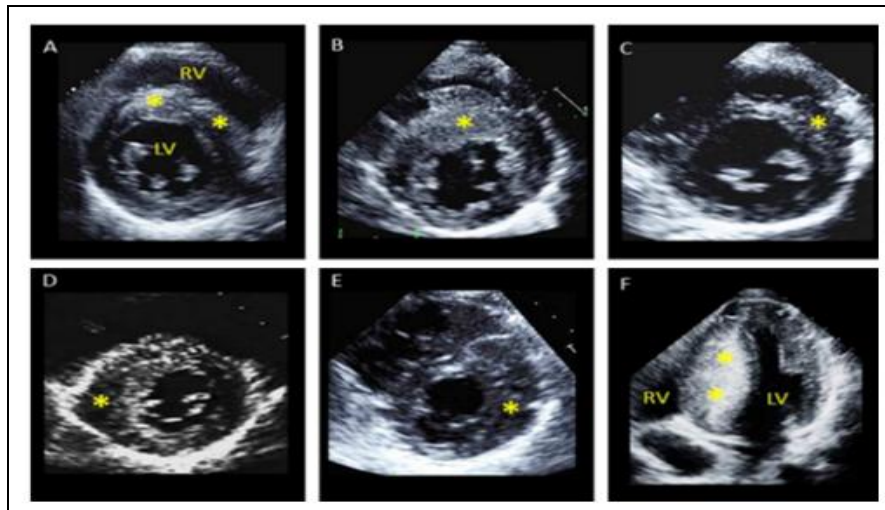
ECHOCARDIOGRAPHIC IMAGES SHOWING PATTERNS OF LV HYPERTROPHY
